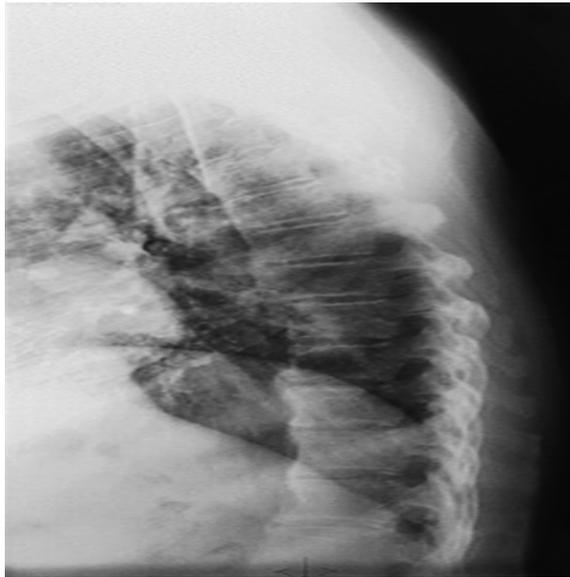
X-ray thoracic spine, lateral view
